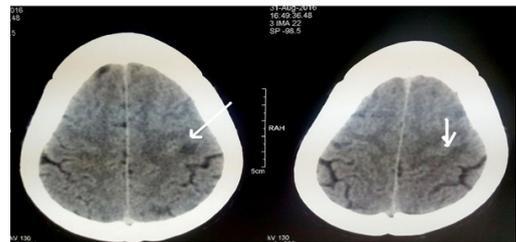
Computed tomography brain showing hypodensity at the left precentral hand knob region marked with arrow suggestive of acute infarct.
